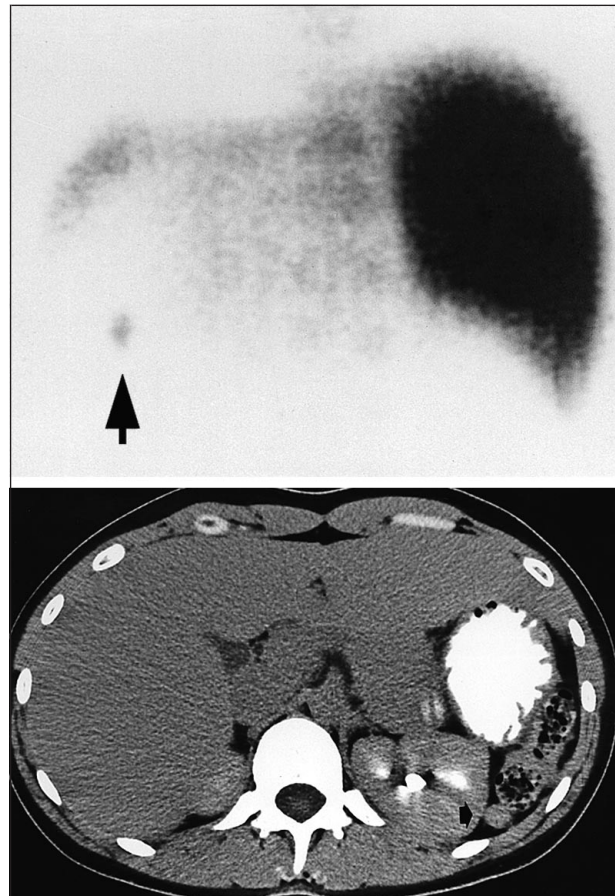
Case 13. A 28-year-old woman with idiopathic thrombocytopenic purpura. The laparoscopic splenectomy was uneventful. The spleen weighed 165 g, and the operative time was 240 minutes. The platelet count after 22 months of follow-up was $40 \times 10^9/L$. Top, Scintigraphy shows an image of isotope pickup (arrow) in the splenic fossa. Bottom, A computed tomographic scan shows an accessory spleen not excised during laparoscopy.
